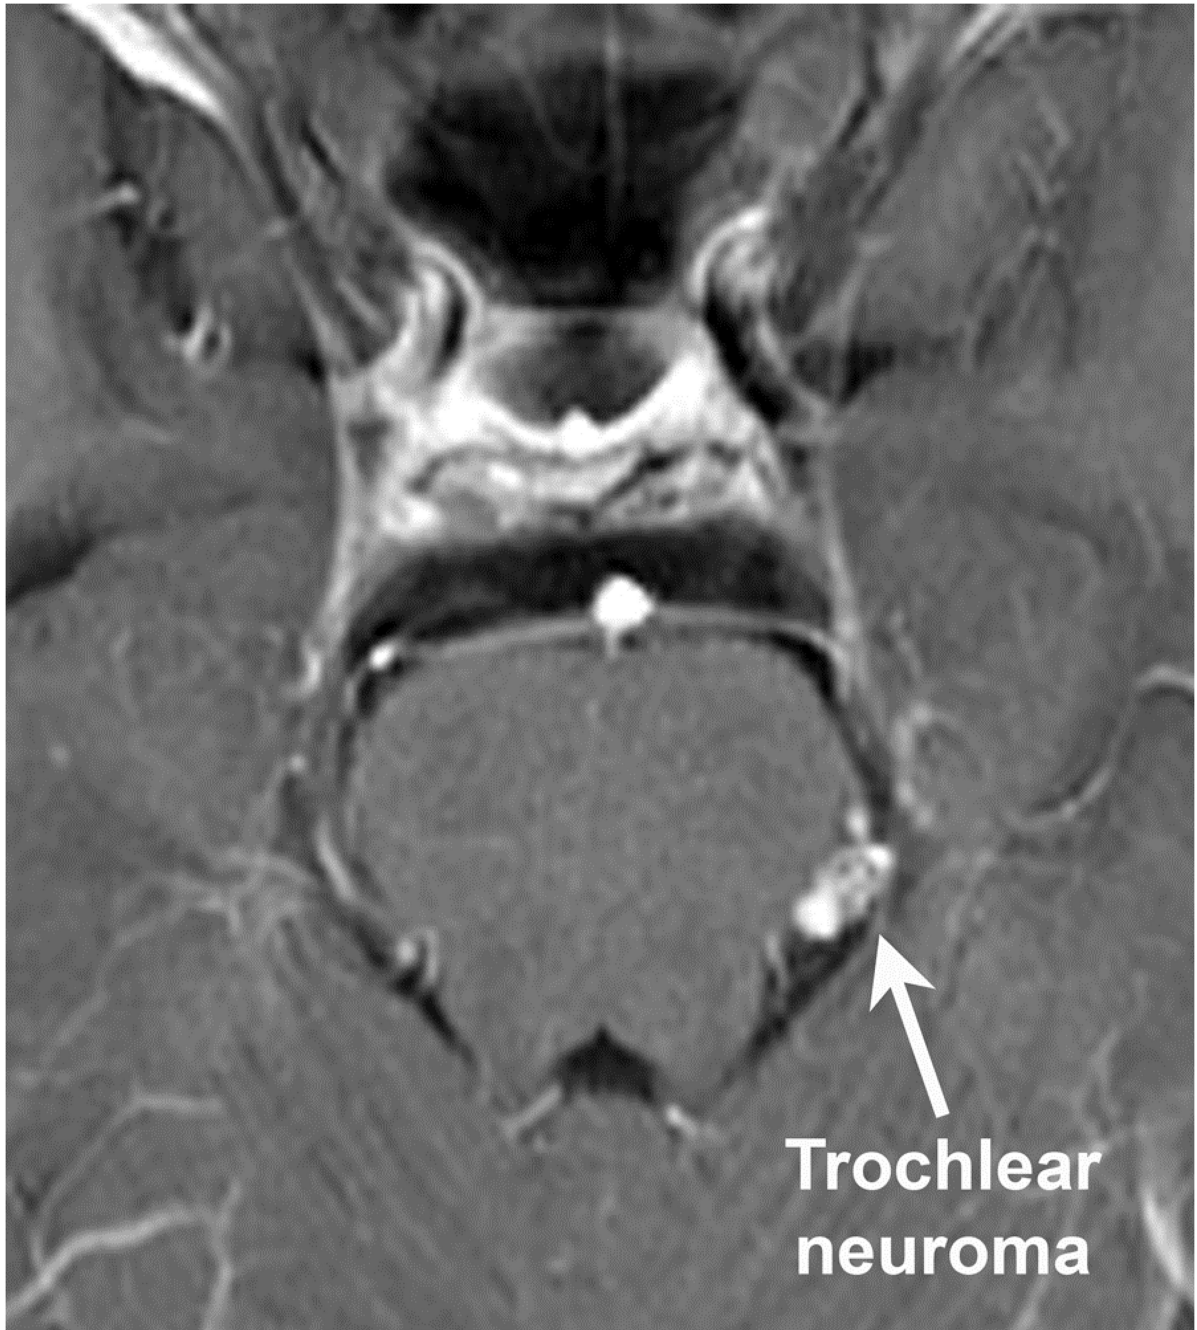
Contrast T1 MRI demonstrating 5 mm enhancing nodule on the subarachnoid trochlear nerve in the left ambient cistern of case 8.
